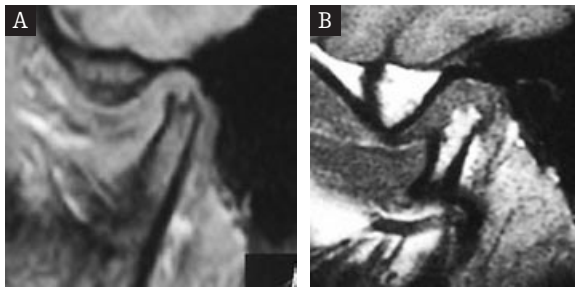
MRI of TMJ. Geodes in mandible head (A). Both articular compartments are filled with solid tissue (B) V° in Wilkes score.
